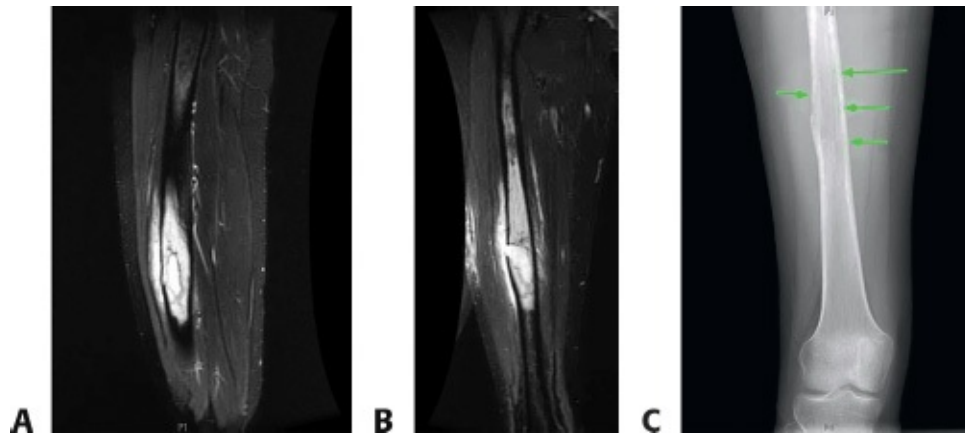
• A. Anterior and lateral (B) preoperative MRIs showing a right midfemur chondroblastoma. C. Plain radiograph of the right femur showing chondroblastoma.
